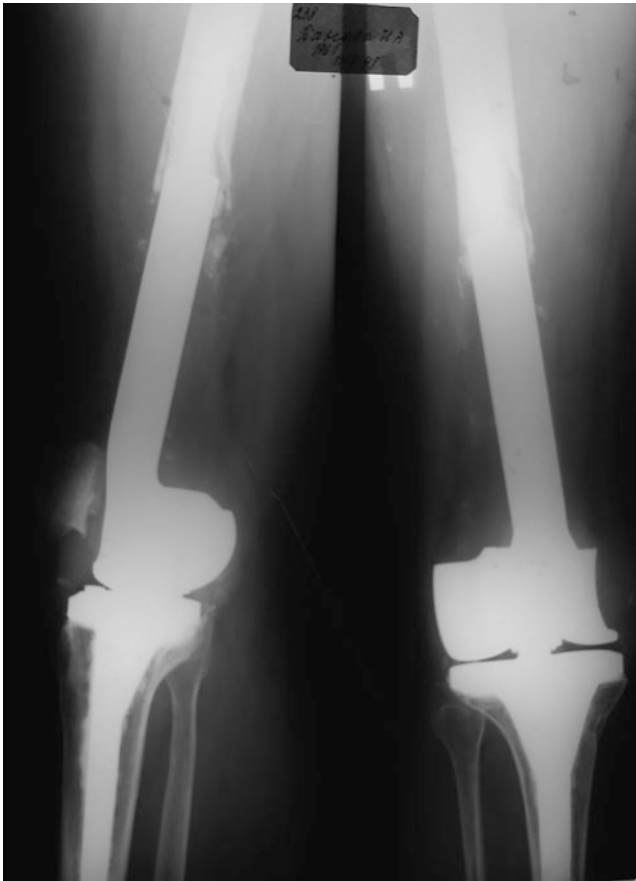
AP/lateral X-rays after sarcoma resection of the distal *right* femur and knee replacement
